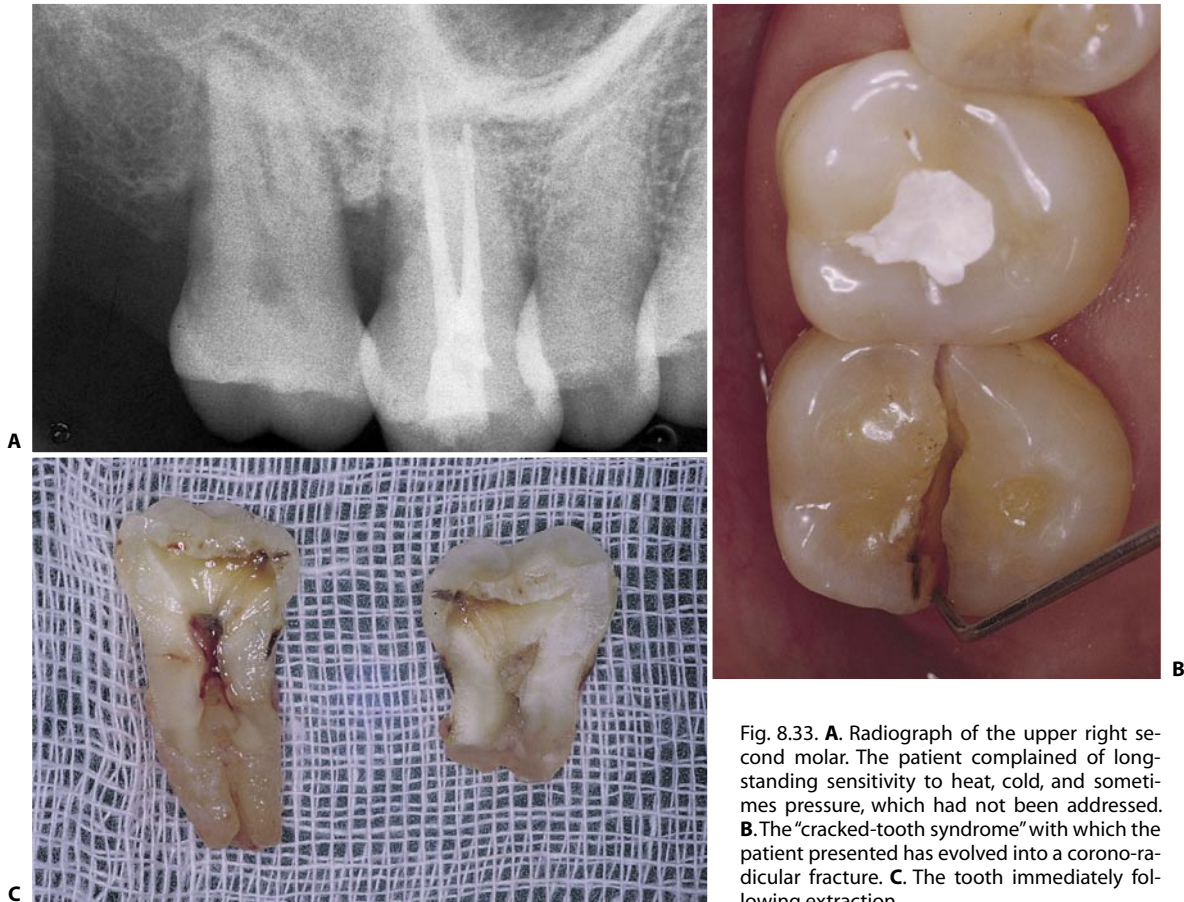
A. Radiograph of the upper right second molar. The patient complained of long-standing sensitivity to heat, cold, and sometimes pressure, which had not been addressed. B. The "cracked-tooth syndrome" with which the patient presented has evolved into a coronoradicular fracture. C. The tooth immediately following extraction.
